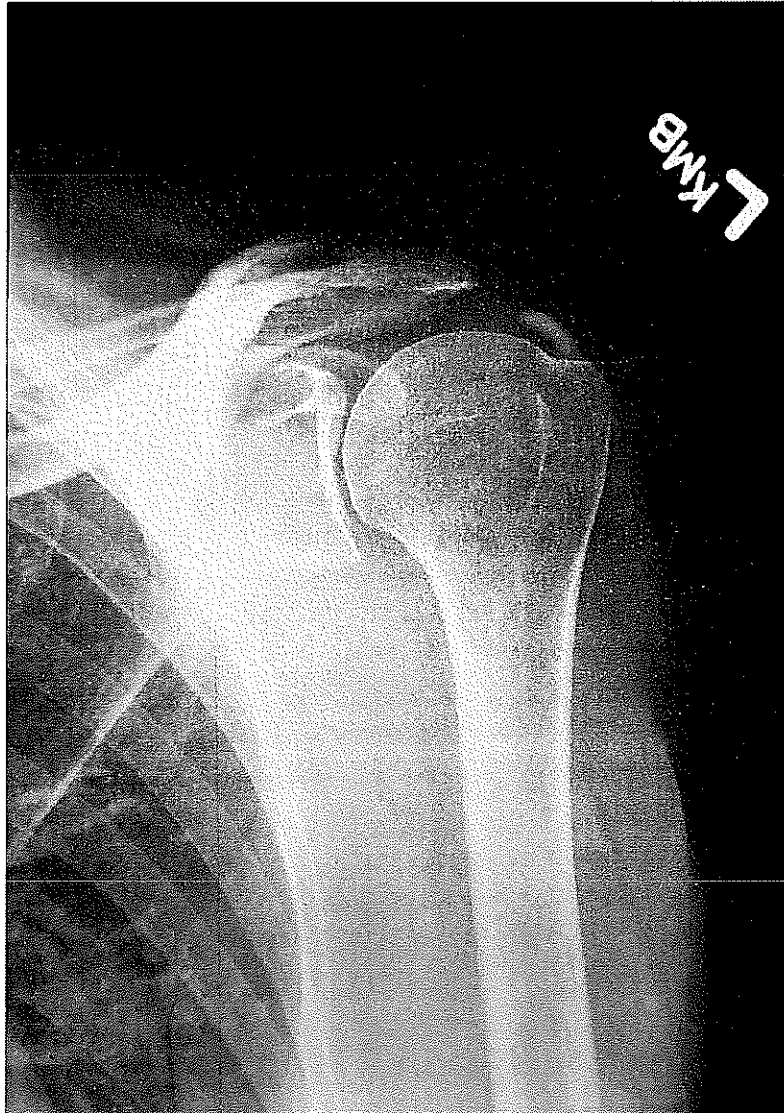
Shoulder X-Ray AP View, Calcific Tendinitis.
